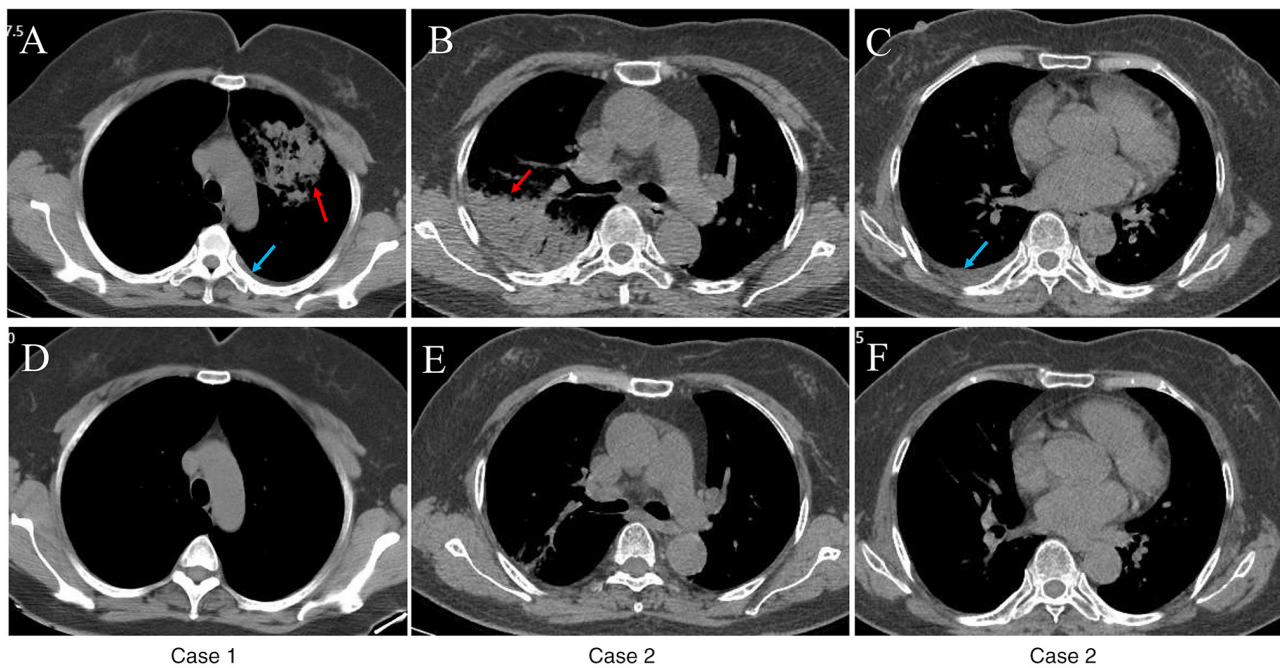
Chest CT radiological features and follow-up changes in the 2 patients with *Chlamydia psittaci* pneumonia. (A) Initial CT (June 2025) revealed patchy opacities with blurred margins and partial consolidation (red arrow) in the left upper lobe, along with a small left pleural effusion (blue arrow) in Case 1. (D) Follow-up CT (July 2025) showing near-complete resolution of the left upper lobe opacities and disappearance of the left pleural effusion in Case 1. (B) Initial CT (October 2025) showing a masslike high-density opacity (red arrow) with blurred margins in the right upper lobe, an arch-shaped area of increased density in the posterior right lower lobe and a (C) small right pleural effusion (blue arrow) in Case 2. (E) Follow-up CT (October 2025) revealing a marked reduction in the size of the masslike opacity in the right upper lobe and (F) complete resolution of the right pleural effusion in Case 2.
